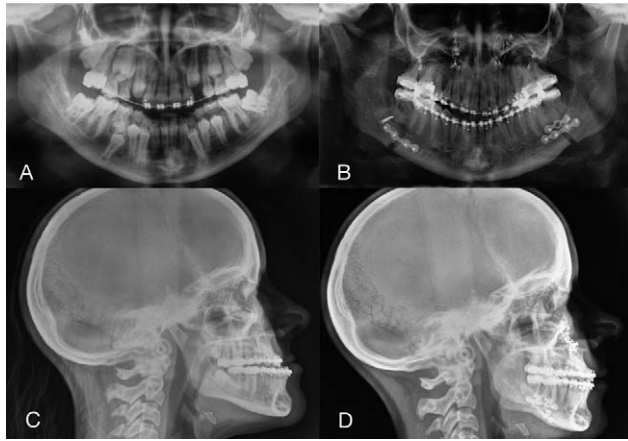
Case 6. Presurgical (A) and postsurgical (B) panoramic x-rays. Presurgical (C) and postsurgical (D) profile teleradiographies.
